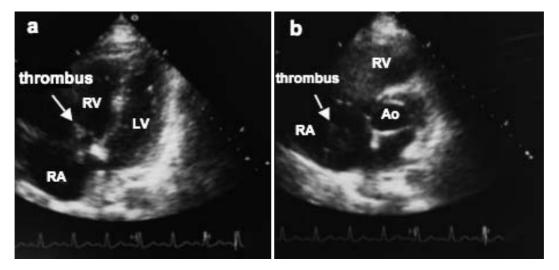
Transthoracic two-dimensional echocardiograms from apical four-chamber view(a) and parasternal short-axis view(b) on admission
